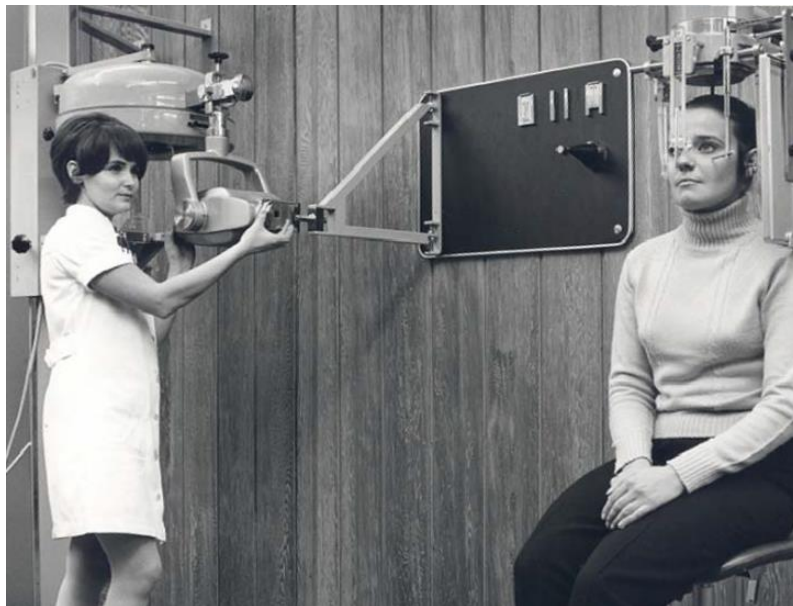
Experimental cephalostat used with the Orthopantomograph OP1 panoramic radiography unit (Instrumentarium, Tuusula, Finland). Two-in-one panoramic/cephalometric units gained popularity in the 1970s with the introduction of the Orthopantomograph OP3 (Fig. 46). Courtesy of Instrumentarium Oy and J. Mudrak.
